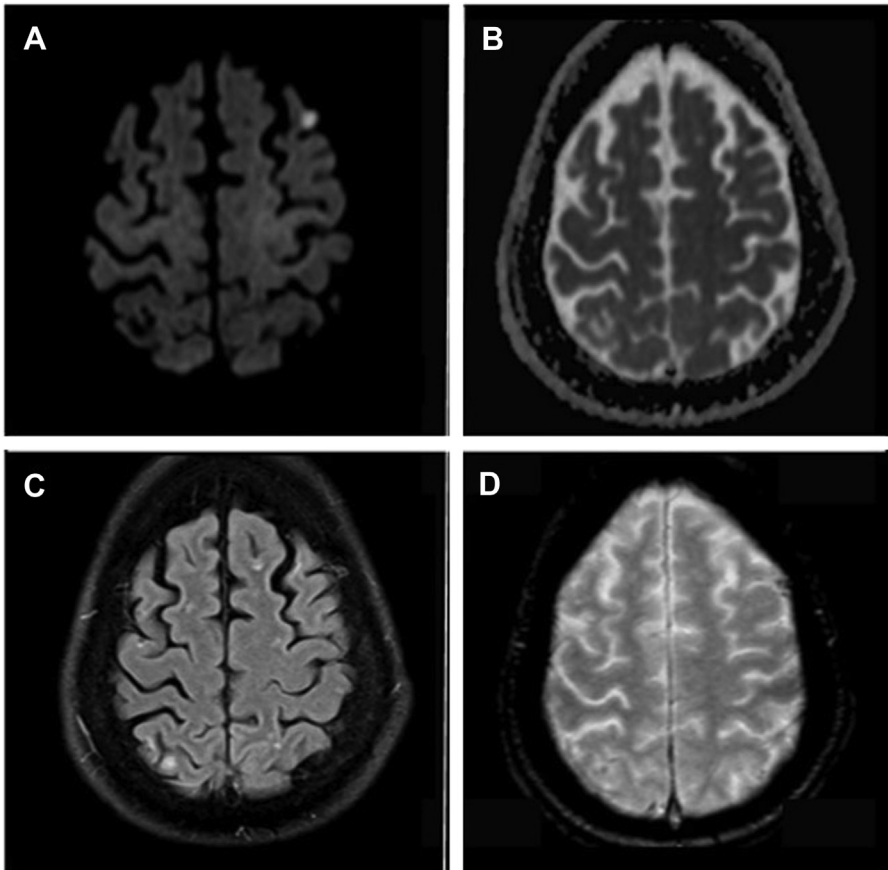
MRI brain without contrast shows an area of restricted diffusion on DWI sequence (A) in the left frontal lobe with apparent diffusion coefficient correlate (B) and no evidence of correlating hyperintensity on FLAIR sequence (C), suggesting an acute infarct. Gradient echo sequence (D) was negative for acute hemorrhage.
